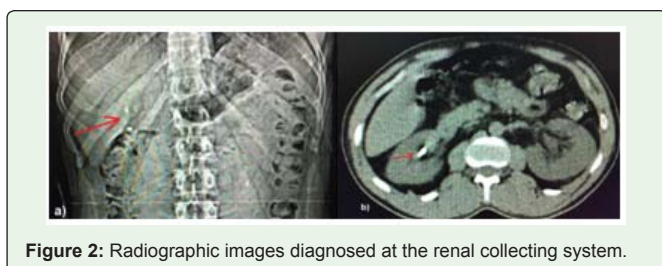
Radiographic images diagnosed at the renal collecting system.
